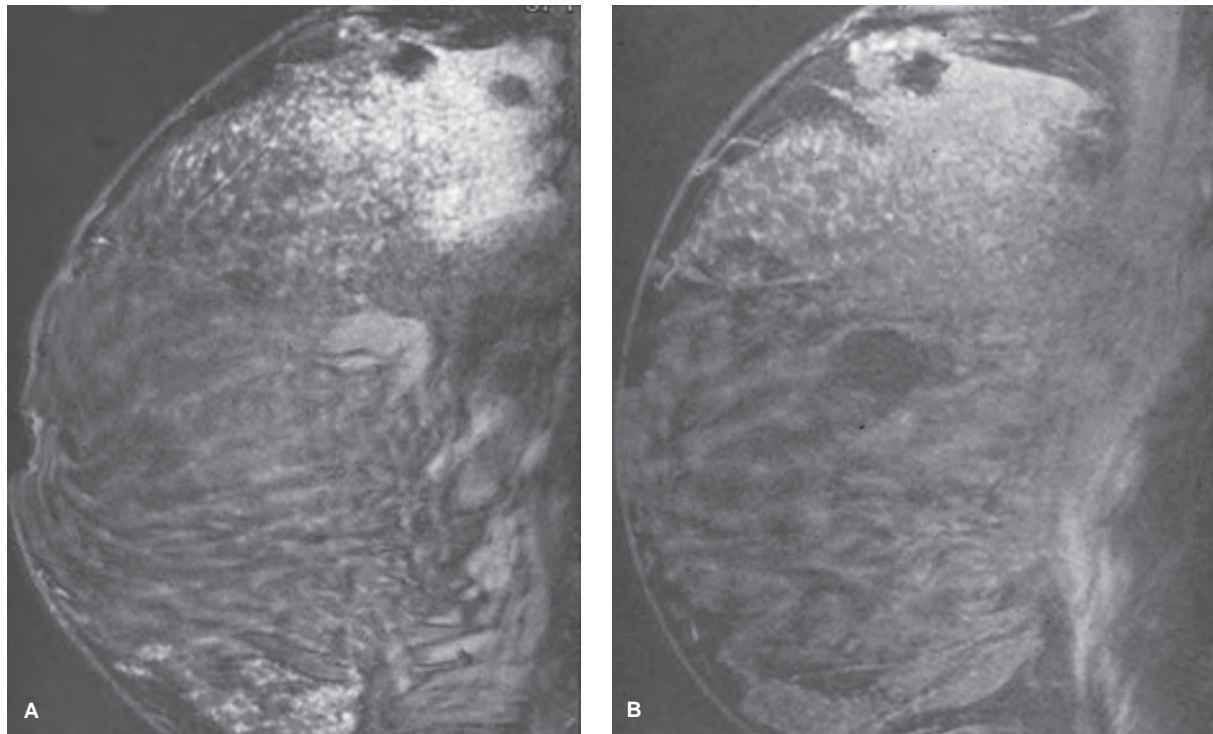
Hormonal variability of contrast enhancement. Sagittal magnetic resonance image of a patient with a family history of breast cancer reveals an area of regional enhancement in the superior breast, which was no longer present when the patient was imaged at a different time in her menstrual cycle.
